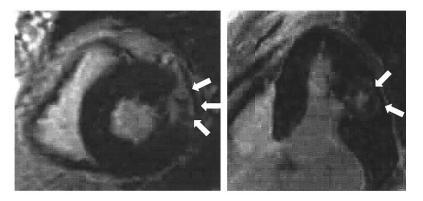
Delayed enhancement magnetic resonance imaging in the short-axis view (Left) and horizontal axis view (Right). Transmural enhancement can be clearly seen in a very narrow range of the lateral wall of left ventricle (arrows).
